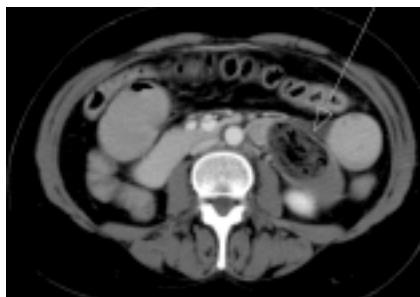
Axial slice of enhanced abdominal CT showing well-defined ovoid intraluminal mass with mottled gas pattern at the site of obstruction in the small bowel (arrow)
